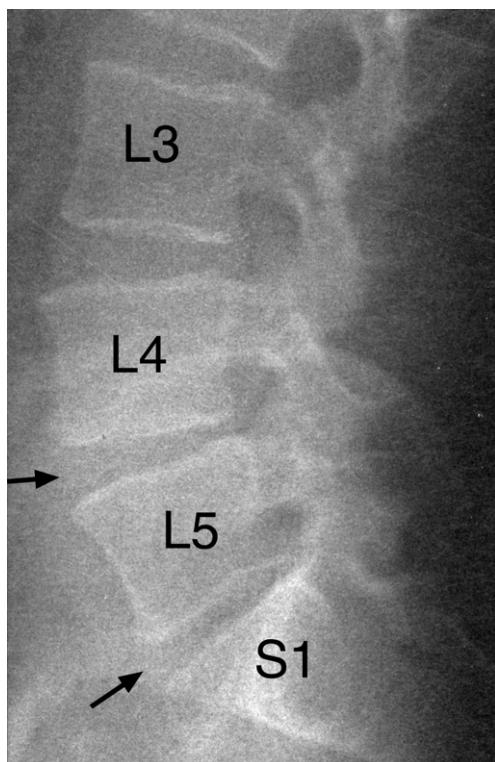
Lumbosacral spine lateral plain X-ray image. Note the slight disc space height narrowing at the L4–5 and L5–S1 levels (arrows) when compared with higher disc levels.
